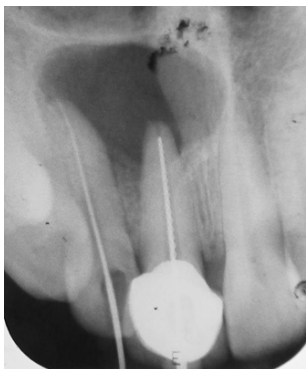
Radiograph Showing Periapical Radiolucency With Well-defined Border
